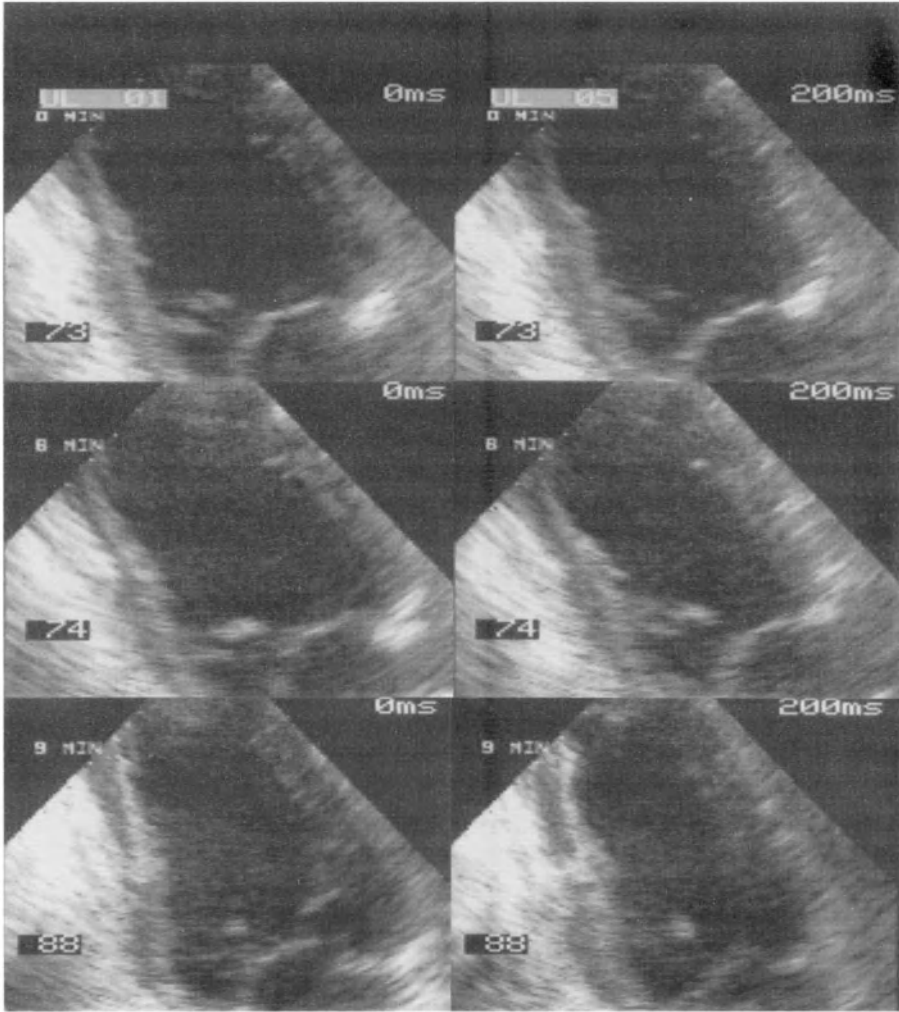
Diastolic (left) and systolic 4-chamber views at rest, after low and high-dose dipyridamole echocardiography in a patient undergoing vascular surgery. The lateral wall (arrows) contracts normally at rest (top), and becomes hypokinetic (middle) and then dyskinetic (bottom) indicating ischemia. At angiography, the patient was found to have circumflex and right coronary disease, and underwent myocardial revascularization prior to vascular surgery.
